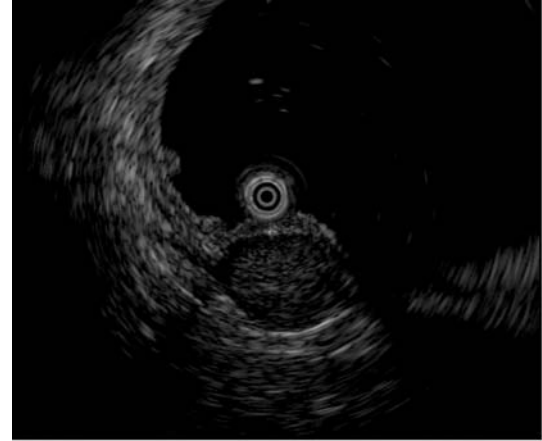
Endoscopic ultrasonography (12Mhz) revealed the tumor as hypoechoic inhomogeneous mass arising from 4th layer, and the diameter was 18mm.
